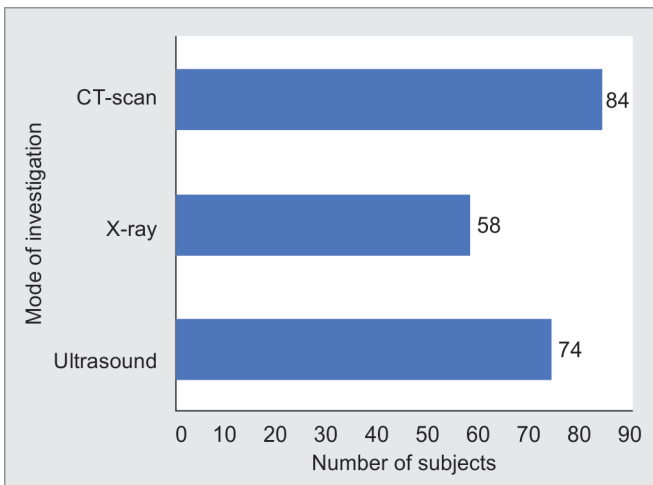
Frequency distribution of detected number of pneumonia cases by BLUS and CXR in comparison to CT scan (n = 85)
